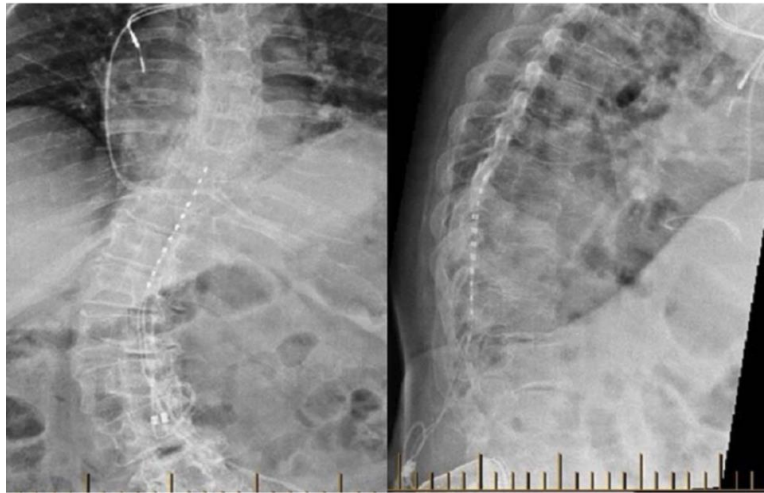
AP and lateral spine X-rays showing implanted stimulator leads.
